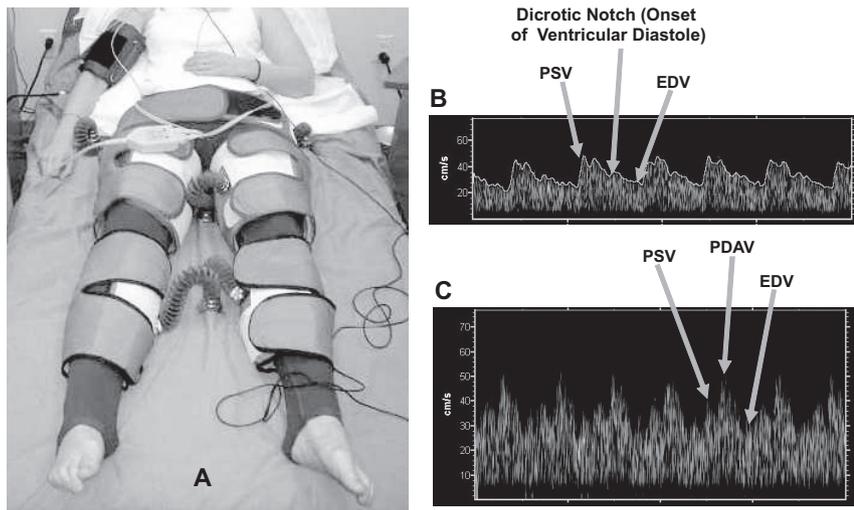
ECP device and normal transcranial Doppler (TCD) waveform compared to ECP TCD waveform.
